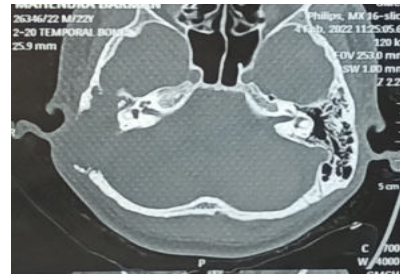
HRCT mastoid of the patient showing soft tissue density and gross bony erosion of right mastoid
